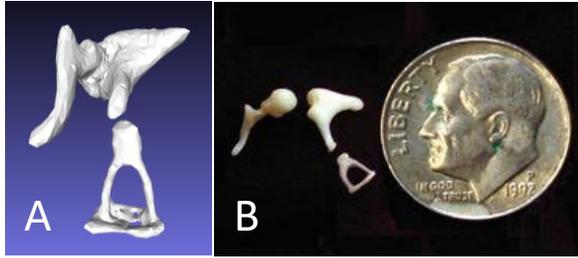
A) Rendered ossicular chain from the micro CT scan from temporal bone of otosclerosis patient. B) Scale of the ossicular chain compared to a dime.
